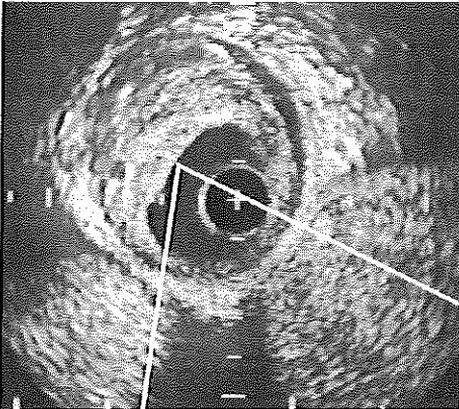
Intravascular ultrasound cross-section obtained from a patient before balloon angioplasty of the superficial femoral artery using the Du-MED system. The lesion involved was eccentric and soft in nature. The hypochoic region seen at 10–11 o'clock may suggest the presence of lipid deposit, but could also be an artifact of attenuation. The arc of disease-free arterial wall is 2 h (5 o'clock). + = catheter; calibration = 1 mm.
